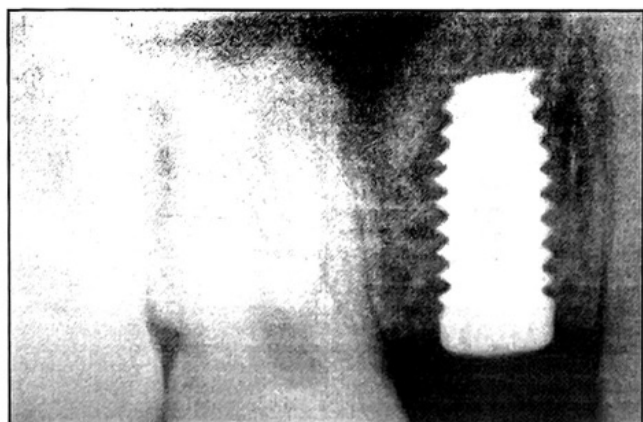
Periapical radiographs immediately after implant placement in the augmented right maxillary sinus.
